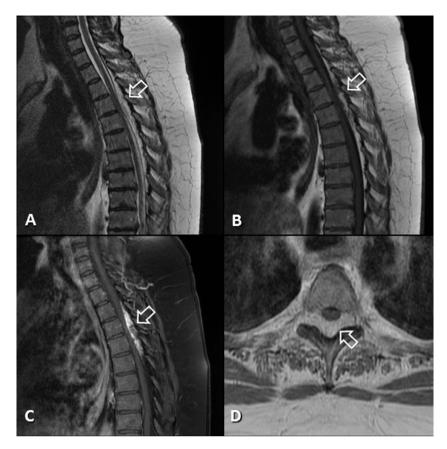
Patient 1. Sagittal T2-weighted (A), sagittal T1-weighted (B), sagittal fat saturated T1-weighted post-contrast (C) and axial T1-weighted post-contrast MRI at the T5/6 level show an enhancing fat containing extradural mass dorsal to the theca and cord that extends from T2 to T6. It anteriorly displaces and moderately compresses the spinal cord, however cord signal is normal. The mass is T2 hyperintense, heterogeneous on T1-weighted imaging with areas of intrinsic high T1 signal that appear to saturate on the fat saturated post-contrast sequence and shows vivid contrast enhancement. The mass extends into bilateral neural foramen at both the T4/5 and T5/6 levels. No bone involvement or destruction.
